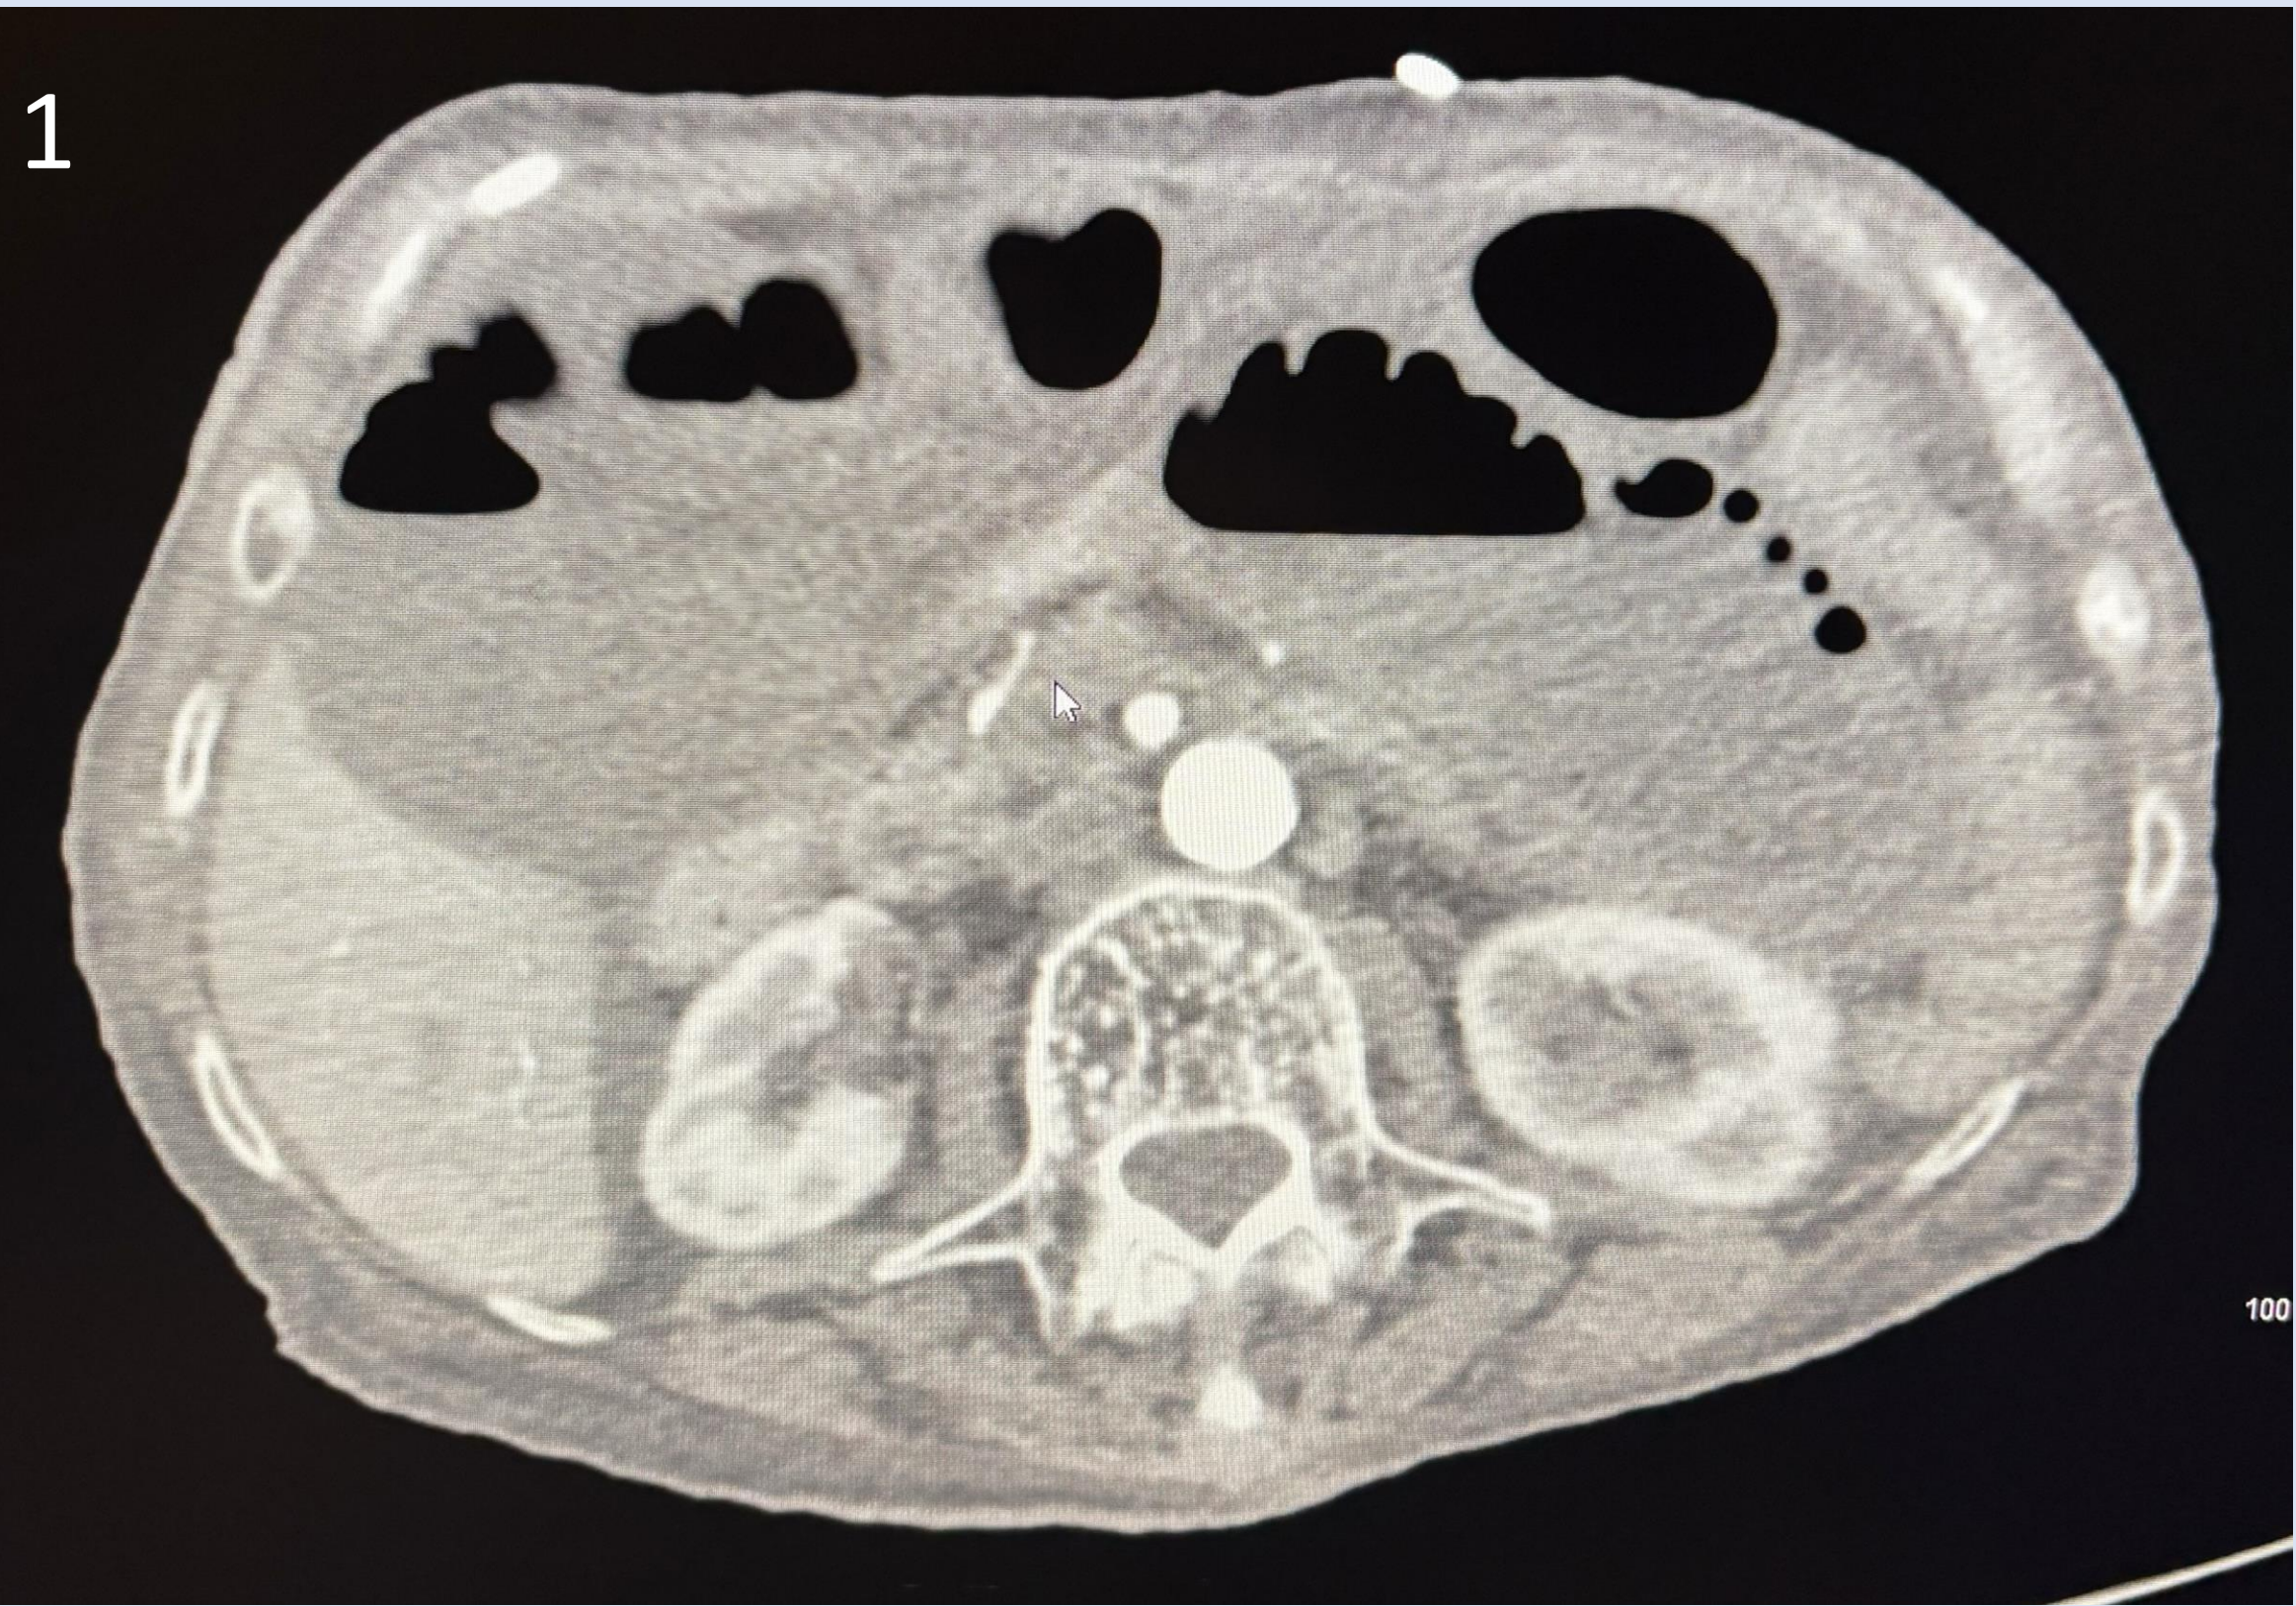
CT of the abdomen and pelvis showing high grade small bowel obstruction with occlusion of the superior mesenteric artery
